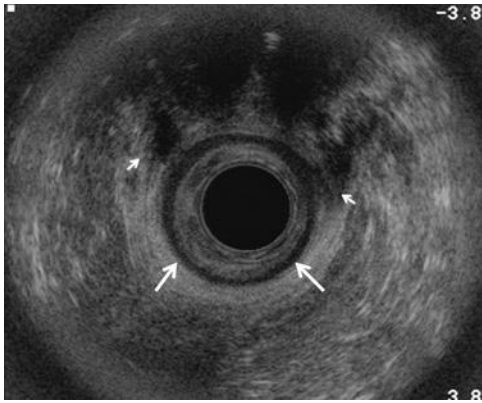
Sphincter tear. Endorectal axial ultrasound image demonstrating an intact hypoechoic internal anal sphincter (arrows), but disruption of the anterior aspect of the external anal sphincter (arrowheads) from the 11 o'clock to the 3 o'clock position.
